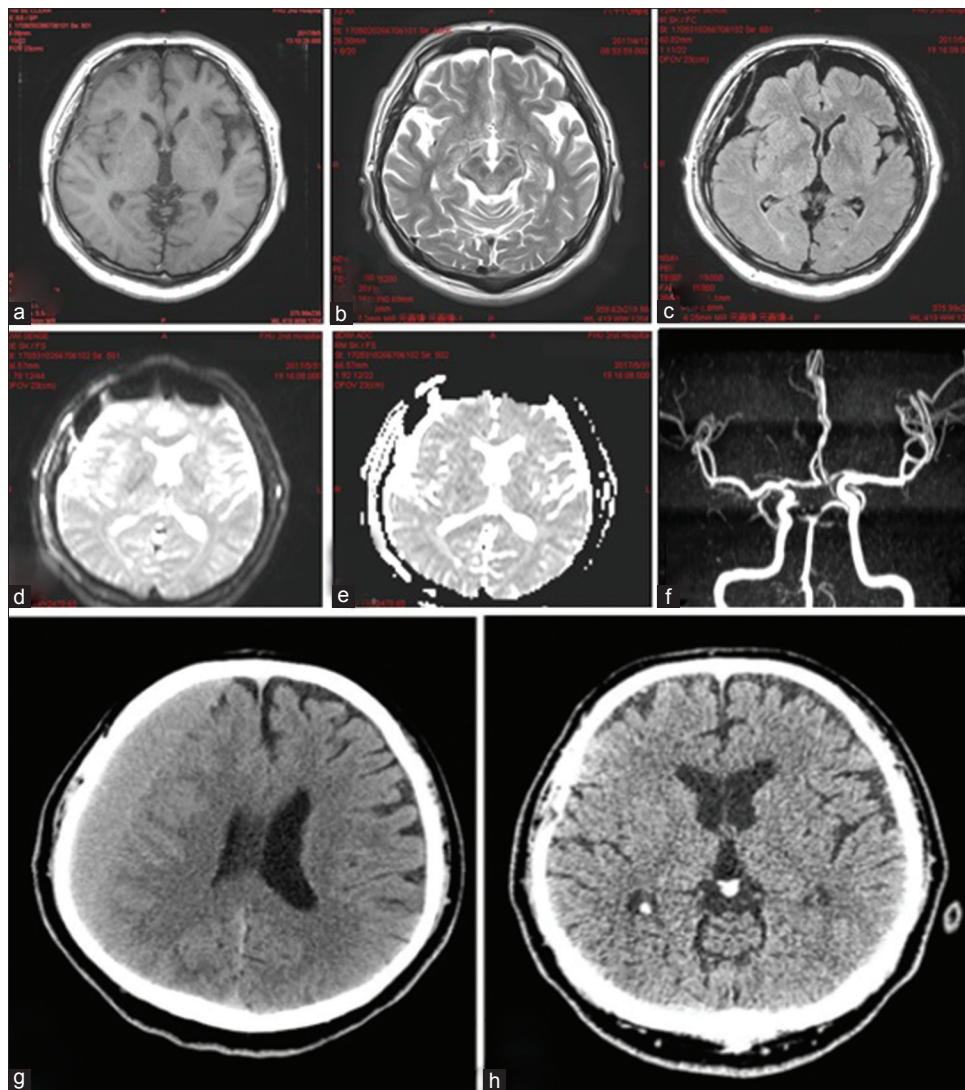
(a-e) Magnetic resonance imaging done on May 31, 2017; (f) Magnetic resonance angiography done on May 31, 2017; (g): Computed tomography scan of the brain done on October 10, 2017; (h) Computed tomography scan of the brain done on October 11, 2017. (a) T1-weighted; (b) T2-weighted, (c) fluid-attenuated inversion recovery; (d) Diffusion weighted Imaging; (e) Apparent diffusion coefficient – No other all the different sequences of magnetic resonance imaging of the brain suggestive of any acute ischemic changes; (f) Magnetic resonance imaging showing no residual aneurysm at the basilar tip with both right internal carotid artery and middle cerebral artery are well seen; (g) Computed tomography scan of the brain (plain) showing right frontoparietal hypo- to isodense subdural collection suggestive of chronic subdural hematoma; (h) Computed tomography scan of the brain showing no residual subdural collection
